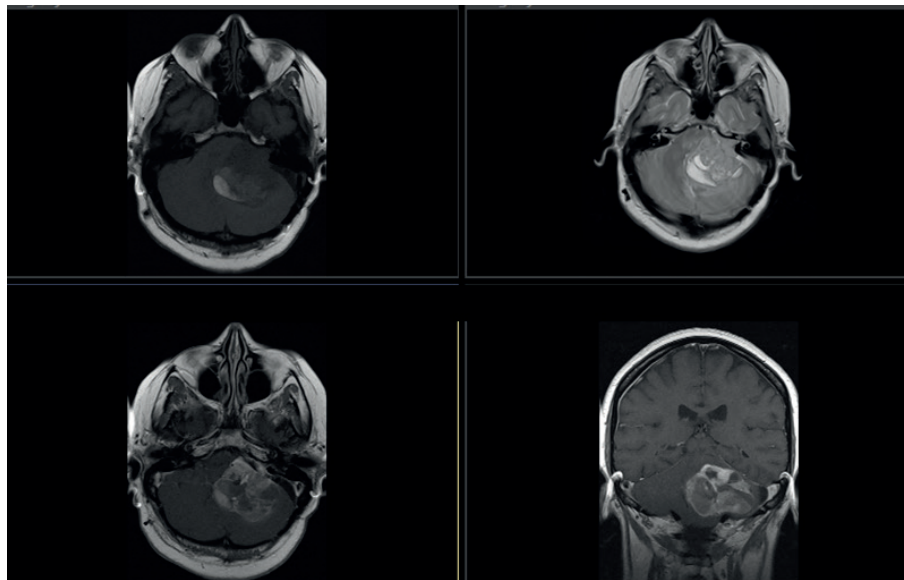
MRI head T1 pre and post contrast and T2 image prior to second surgery.
